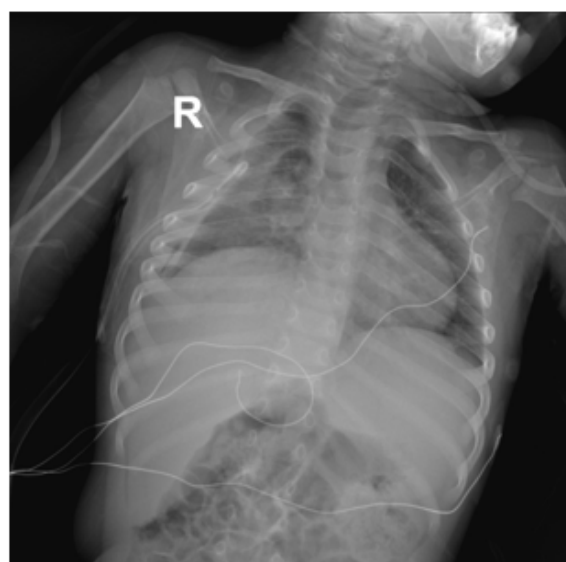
Xray follow up.
